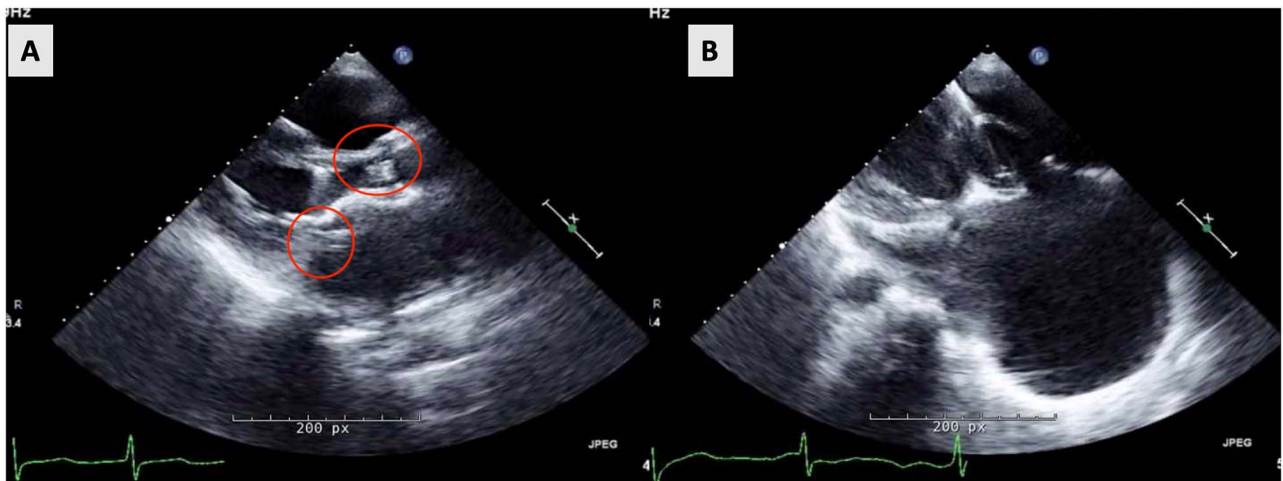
Transthoracic echo. (A) Long-axis view; thickening of aortic and mitral leaflets and dilated RV. (B) Four chamber view; marked dilated RA no thrombus seen.
